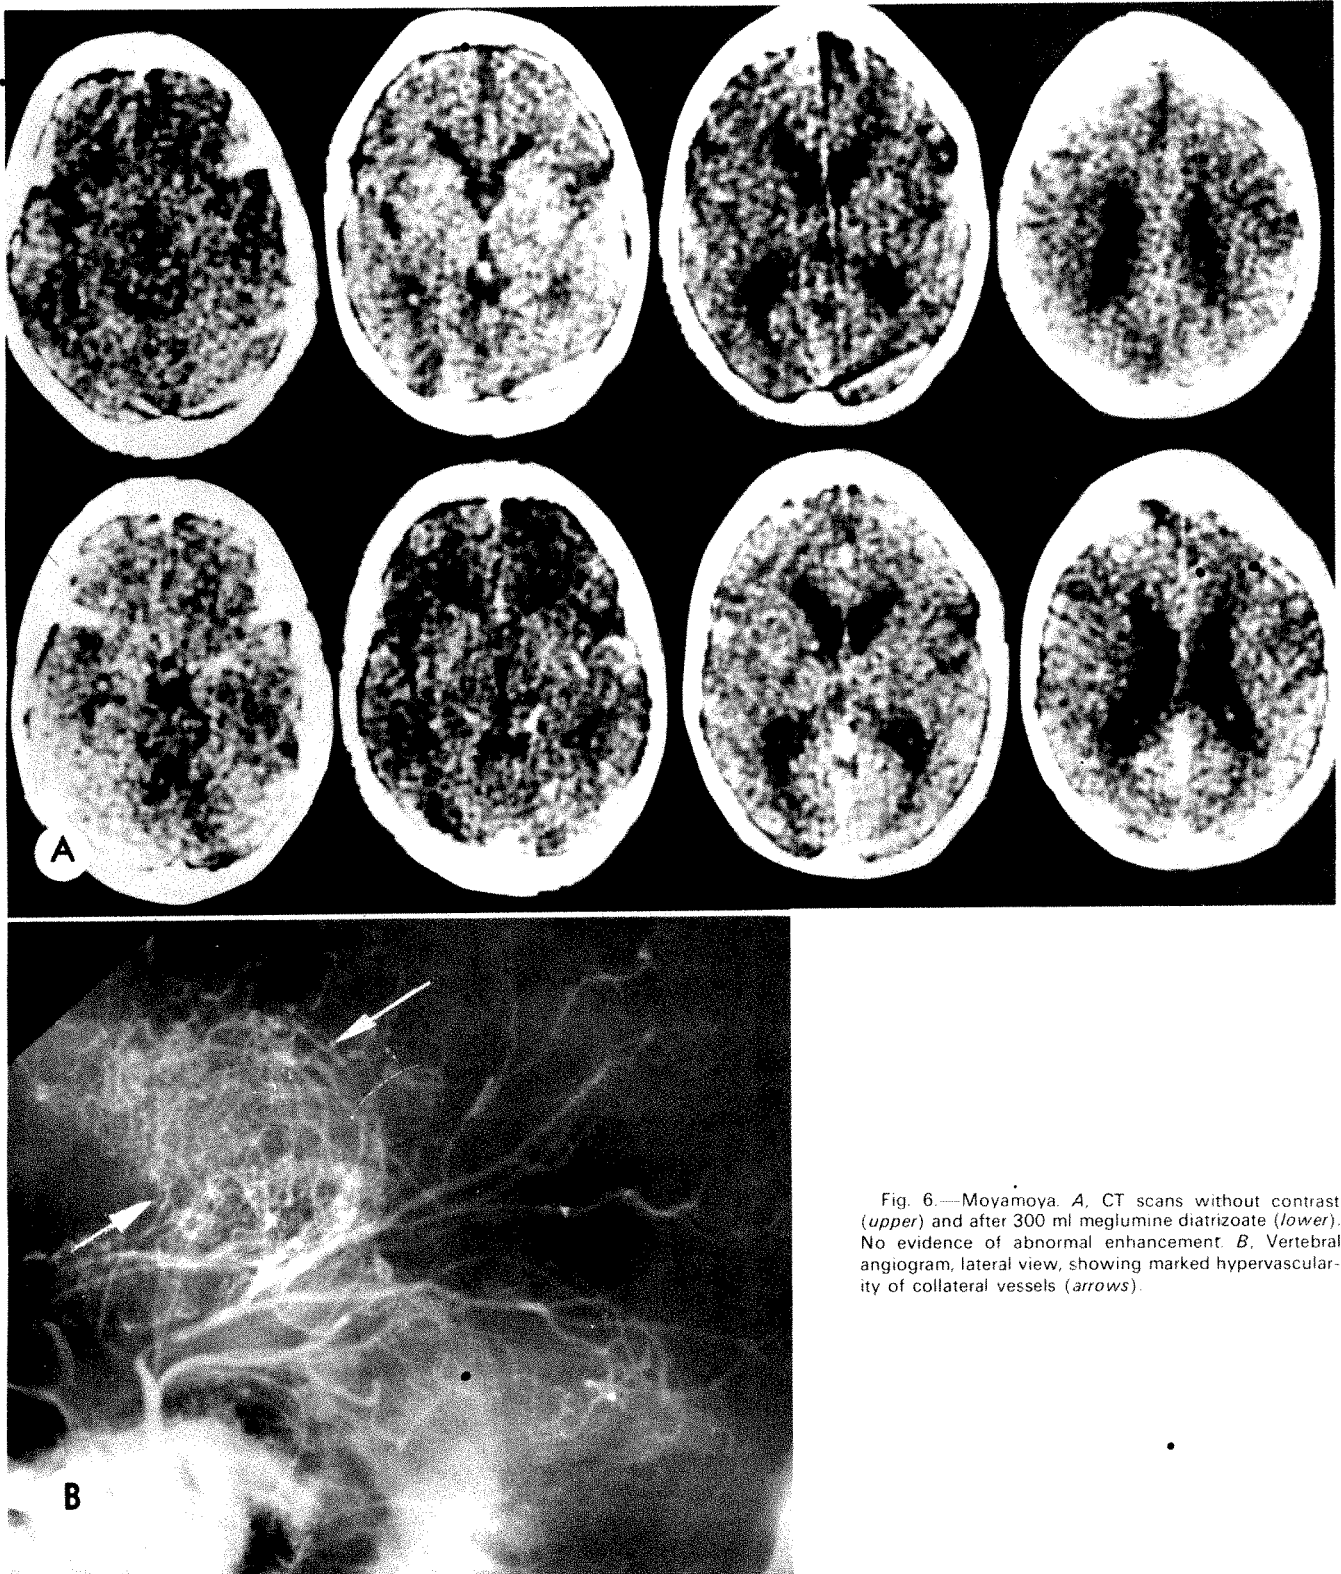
Moyamoya. A. CT scans without contrast (*upper*) and after 300 ml meglumine diatrizoate (*lower*). No evidence of abnormal enhancement. B. Vertebral angiogram, lateral view, showing marked hypervascularity of collateral vessels (*arrows*).
